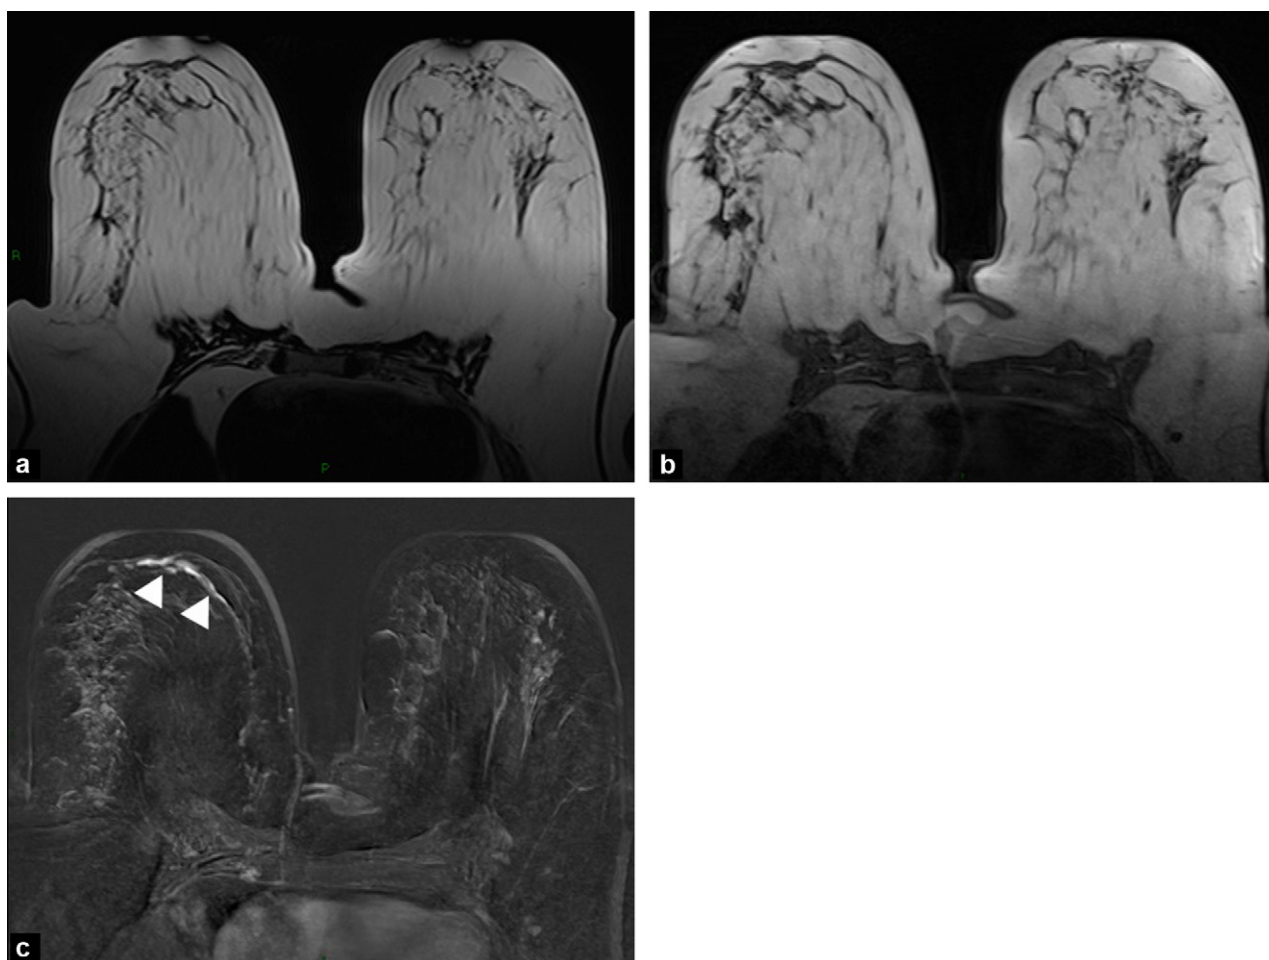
Breast MRI: axial T2-weighted (a), T1 (b), T1 injected with subtraction (c).
